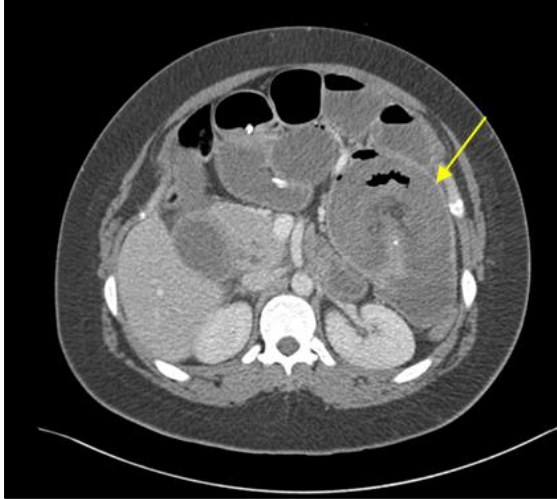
CT scan showing small bowel intussusception (yellow arrow).
